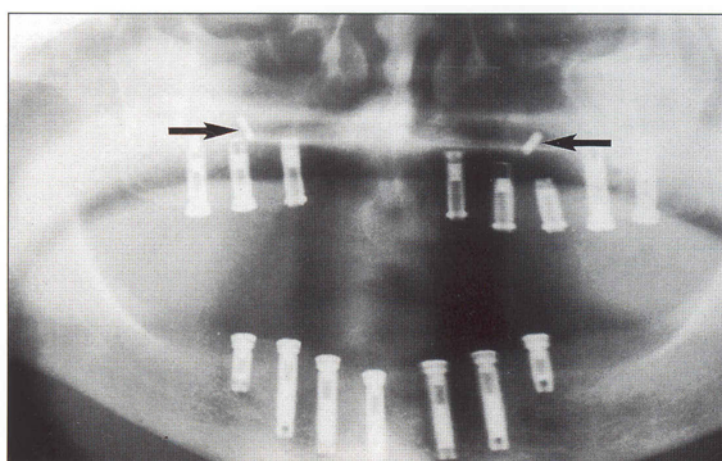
Radiograph of a patient treated with implants and bilateral maxillary sinus floor augmentation. Note the microimplants (*arrows*).
